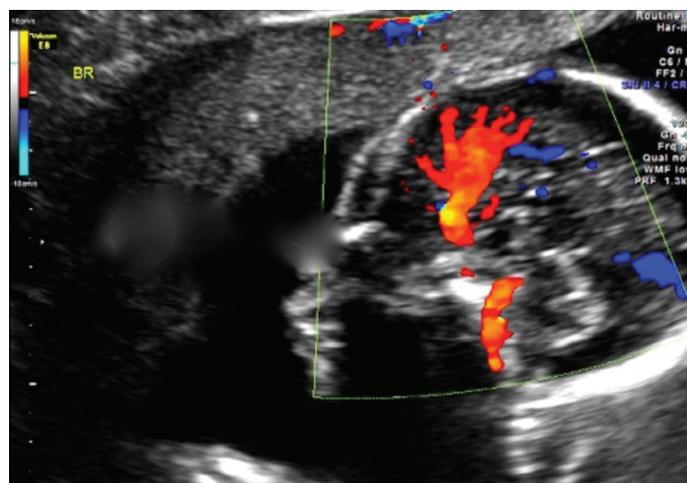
Sonographic appearance of absent corpus callosum: Please note that the abnormal branching of the anterior cerebral artery is due to the absence of the pericallosal arteries. (Courtesy of D Cohen, MD)
